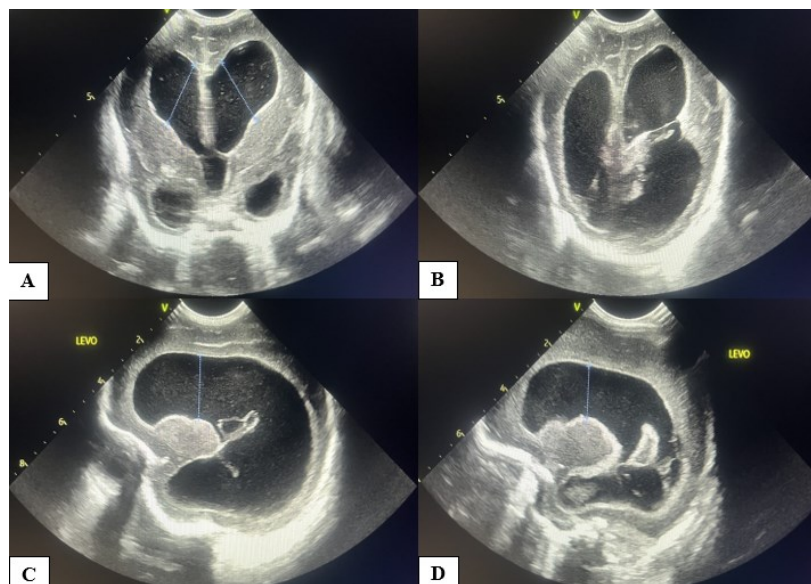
Head ultrasound showed posthemorrhagic ventricular dilatation, the presence of intraventricular debris and stranding in lateral ventricles, with fibrin sept formation in left lateral ventricle. A and B: coronal images, C and D: sagittal images.
